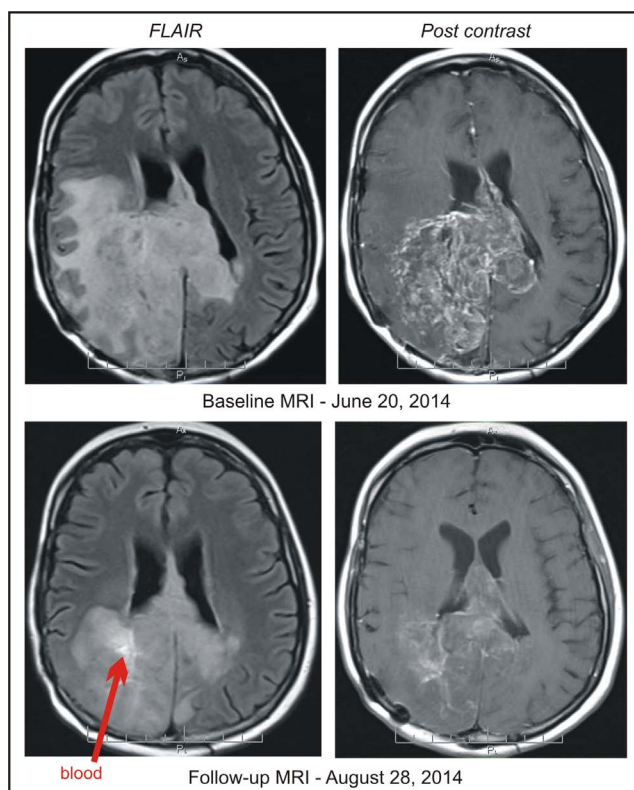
Patient 9, baseline and follow-up MRI of the head indicating partial response.
